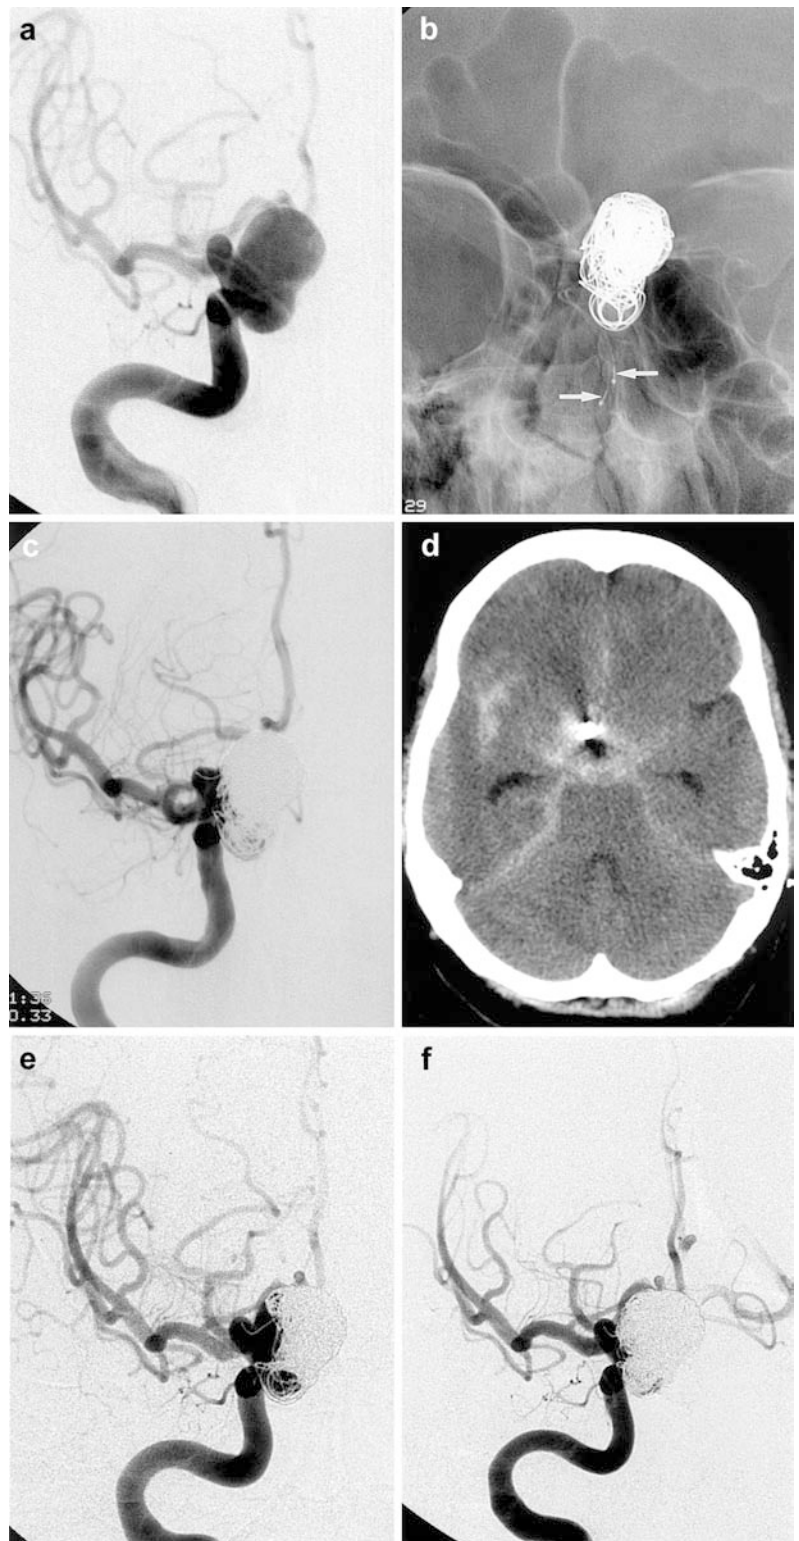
Patient 4. Haemorrhage during catheterising an aneurysm, with extravasation of contrast medium and slight elevation of systolic blood pressure. a A ruptured aneurysm at the origin of the posterior communicating artery. To catheterise the aneurysm were advanced an Excelsior catheter and an Agility 14 wire to it, whereupon the tip of the wire suddenly passed through its wall. b One GDC was promptly inserted into the aneurysm, using on a roadmap image which showed active extravasation of contrast medium (*arrows*). Systolic blood pressure rose by 30 mm Hg. We placed two further were placed to exclude the aneurysm from the circulation and stop the extravasation. c Angiography showed subtotal occlusion of the aneurysm and no extravasation. At the end of the procedure systolic blood pressure was normal. d CT immediately after the procedure revealed high density in the subarachnoid space
